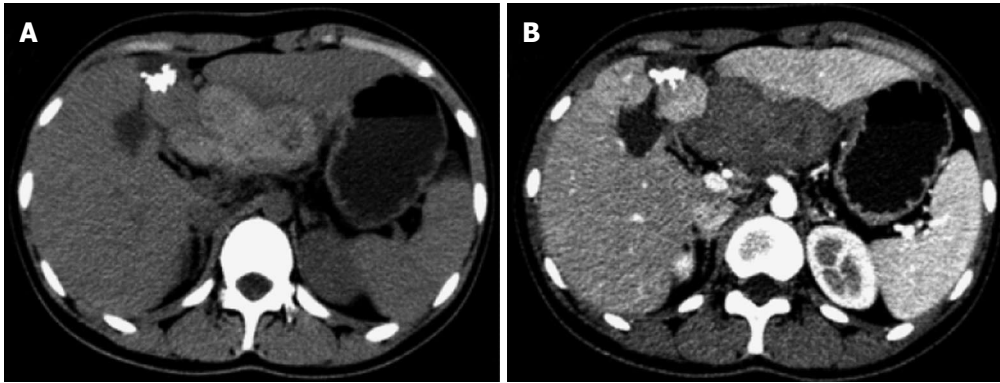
Radiographic findings. A: A non-enhanced computed tomography (CT) scan revealed two masses in the liver, one of which contained a high-density nodule; B: A contrast-enhanced CT scan obtained during the hepatic arterial phase showed no enhancement in or around the masses.
